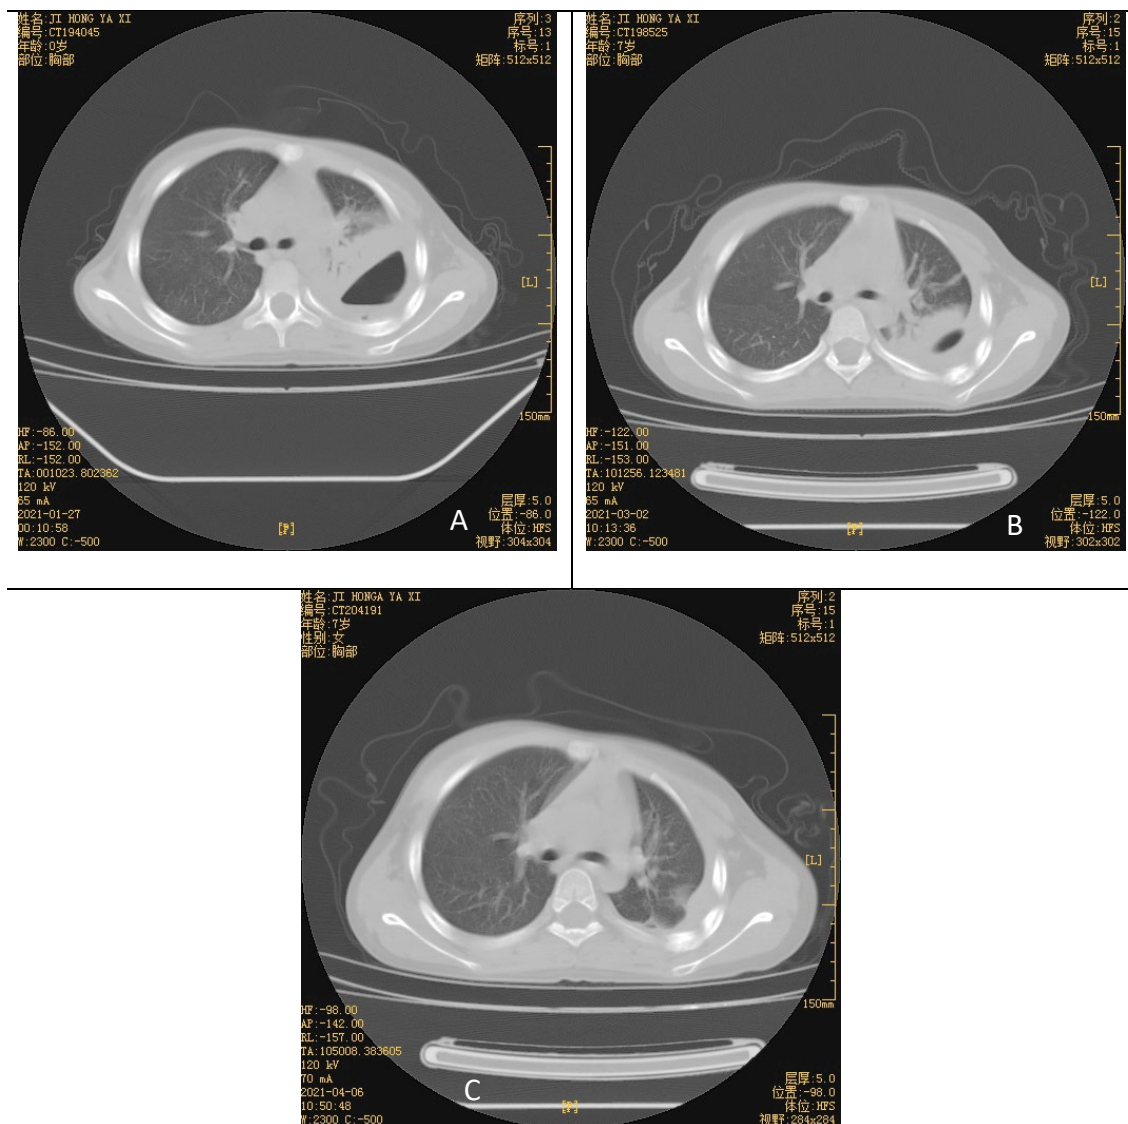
Chest CT evolution of case two. (A) The chest CT on admission showed vast dense consolidation containing an air-fluid level in the lower lobe of the left lung and left thoracic cage had slightly collapsed. (B) Repeated chest CT one month later showed the consolidation area and air cavitation inside were remarkably narrowed. (C) Follow-up CT at a one-month interval revealed the consolidation segment and lucent cavity had disappeared with local thickening pleura and a small ground glass shadow left.
